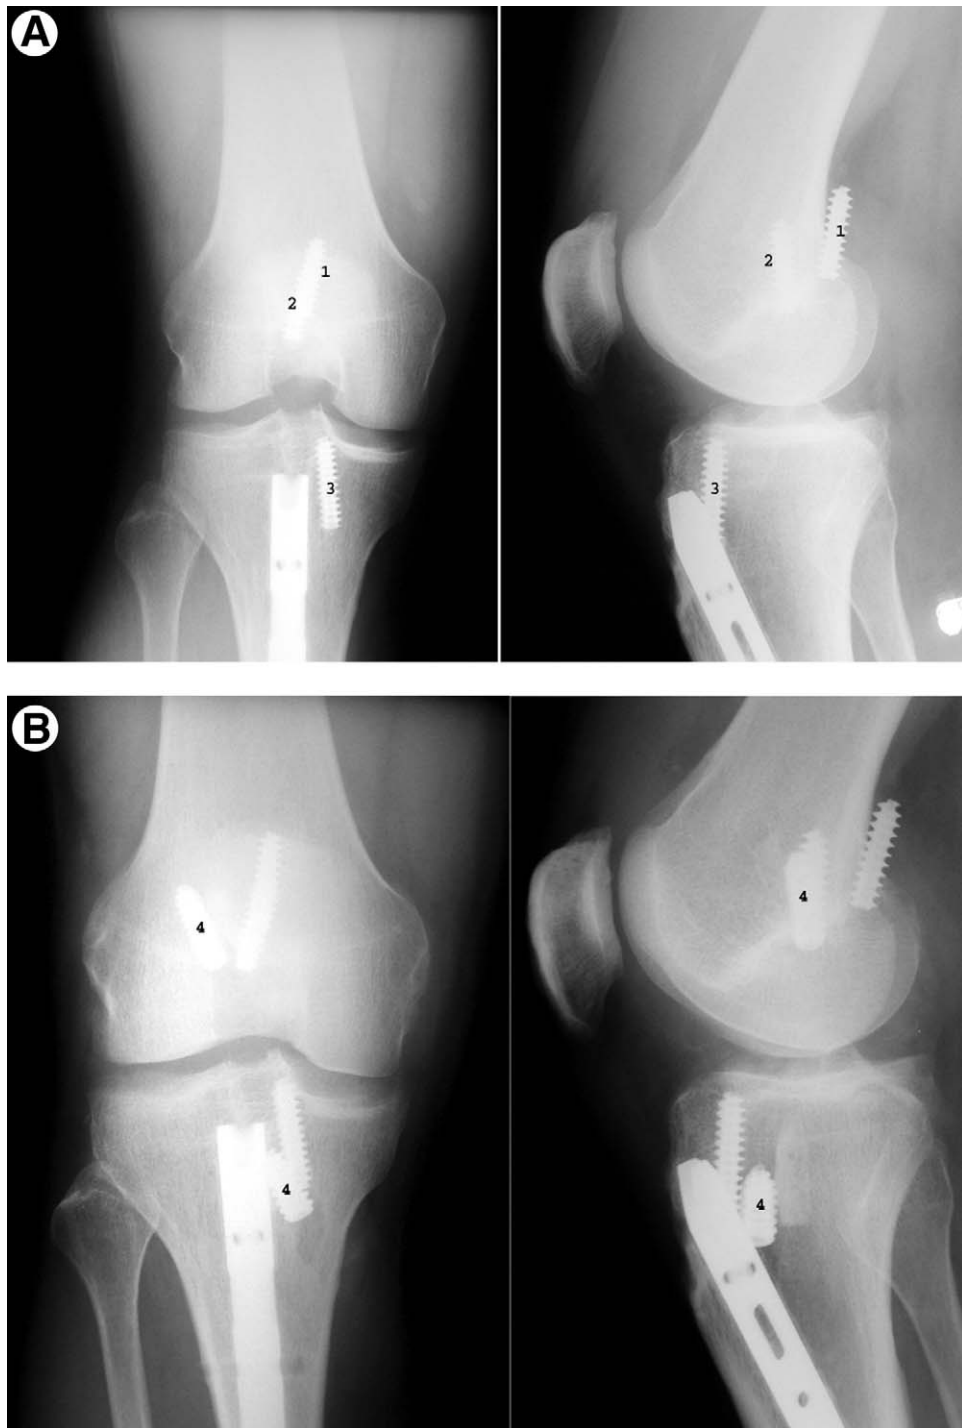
(A) Pre-revision radiographs demonstrating femoral malpositioning. (1) Interference screw positioned in the posterior soft tissues; (2) second screw aiming medially, thus diverging from the femoral tunnel; (3) it is preferable to use a 9 mm interference screw for improved tibial fixation. (B) Postoperative radiographs demonstrating revision ACL reconstruction bypassing preexisting hardware. (4) Revision interference screws in correct position. The interference screw in the posterior soft tissues was not removed to avoid extensive dissection close to the neurovascular bundle.
